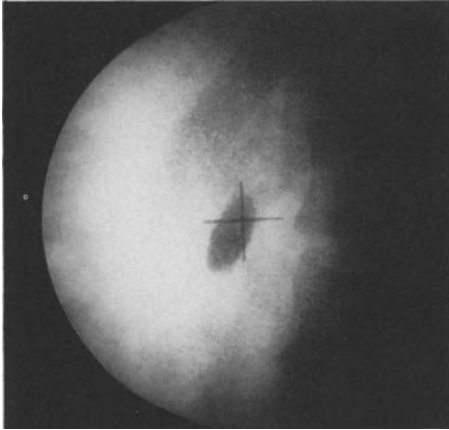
Radiological follow-up of a right pelvic stone. a AP roentgenogram (KUB) prior to treatment. b 0 pulses. c After 150 pulses. d After 400 pulses. e After 600 pulses. f Final AP film after treatment
